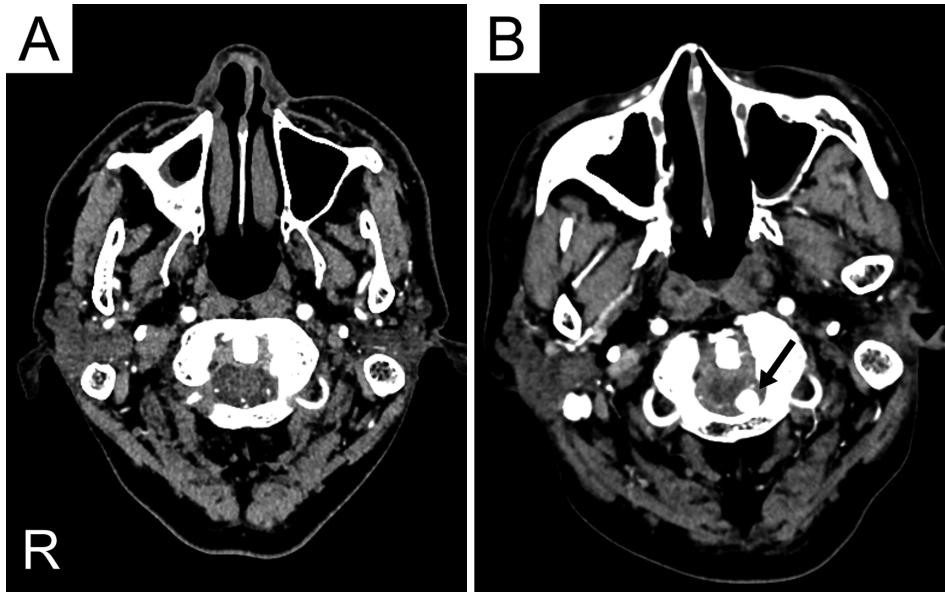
A showing axial cut of CTA depicting the PICA without an associated aneurysm. B showing similar cut conducted 1 month later, revealing a left PICA aneurysm. The arrow indicates the aneurysm.
